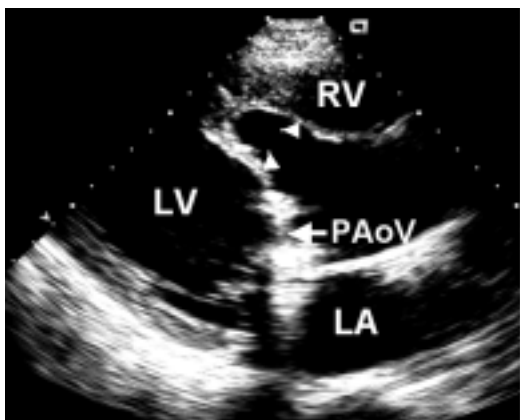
Parasternal long-axis view during systole showing the dissected interventricular septum (arrowheads) and prosthetic aortic valve (PAoV, arrow). RV = right ventricle, LV = left ventricle, LA = left atrium.
